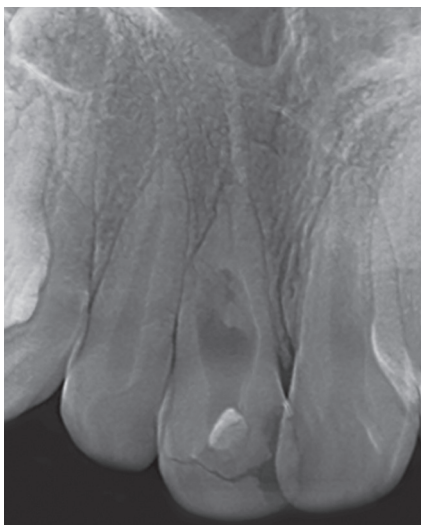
Preoperative periapical radiograph suggesting internal root resorption.
